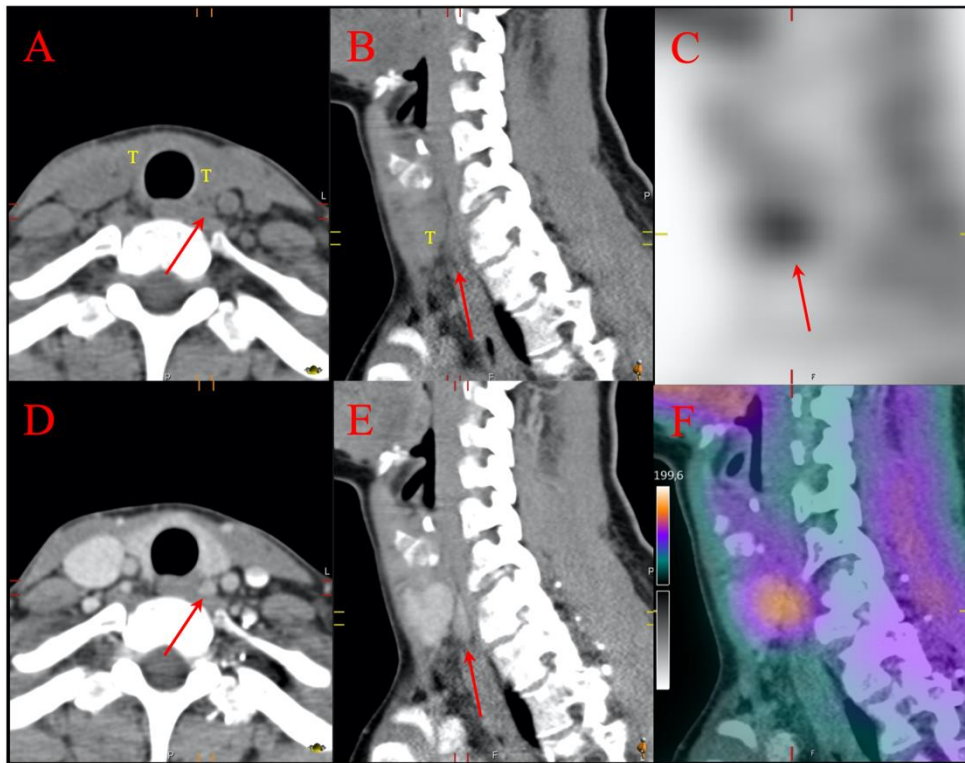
Low and similar attenuation in the thyroid gland (yellow T) and a parathyroid adenoma (red arrow), not clearly distinguishable in non-contrast enhanced CT (A and B). The parathyroid adenoma is detected mainly due to the distinct focal sestamibi uptake (C and F), but the contrast enhancement facilitates the outlining of a soft tissue nodule behind the thyroid (red arrow in D and E).
